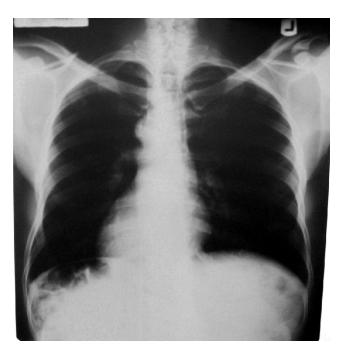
Poster anterior chest radiograph in a 53-year-old man with situs inversus and dextrocardia. This image shows that the cardiac apex points to the right. A right-sided aortic arch is associated with slight deviation of the trachea to the left. The stomach bubble is visible in the right upper quadrant
